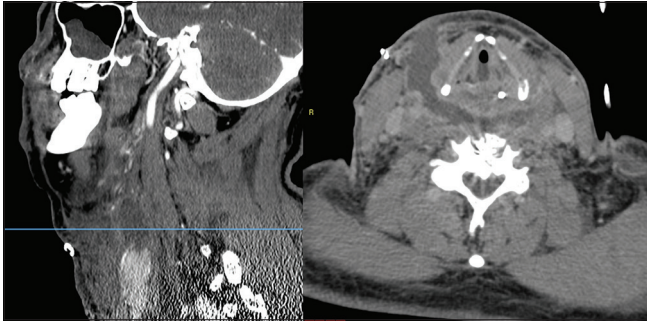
Post-operative sagittal (left) and axial (right) CT angiography scan sequences proving the successful evacuation of the retro-tracheal hematoma and the absence of further vessel abnormalities.
